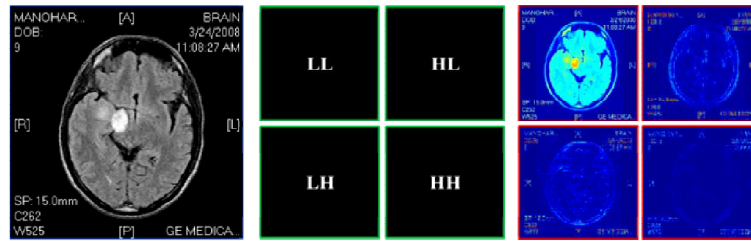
The two-dimensional discrete wavelet transform in four directions for MR image.
